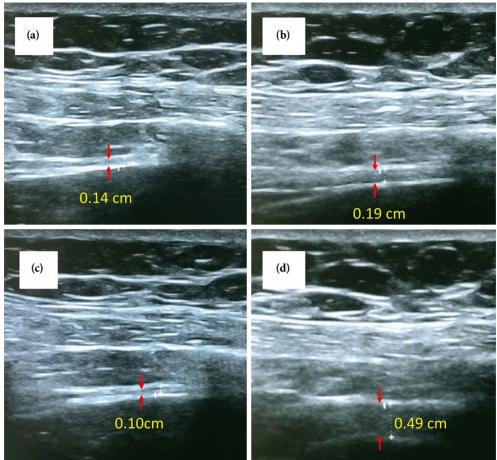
Diaphragmatic ultrasound images obtained from the eighth or ninth intercostal space along the anterior axillary line on the (a, c) left and (b, d) right sides. On the affected (left) side, (c) a paradoxical decrease in diaphragm thickness is observed during forced inspiration compared to expiration (a). On the unaffected (right) side, diaphragm thickness increases (d) appropriately during inspiration compared to expiration (b), with a thickening fraction calculated of 158%.
